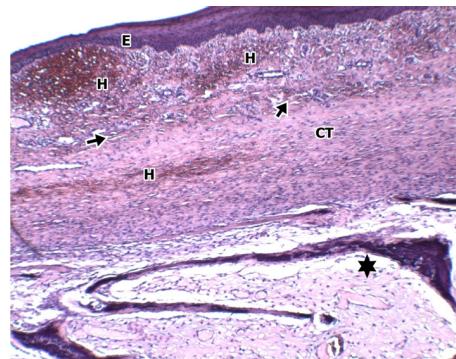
Nonstratified squamous epithelium (E), multifocal haemorrhage (H), connective tissue (CT), capillaries (arrows) and remnants of teeth (star) $\times 40$, H/E.
